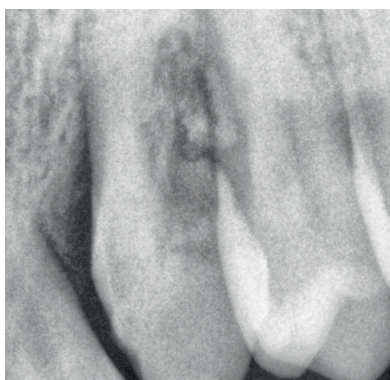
Intraoral X-ray before treatment.
